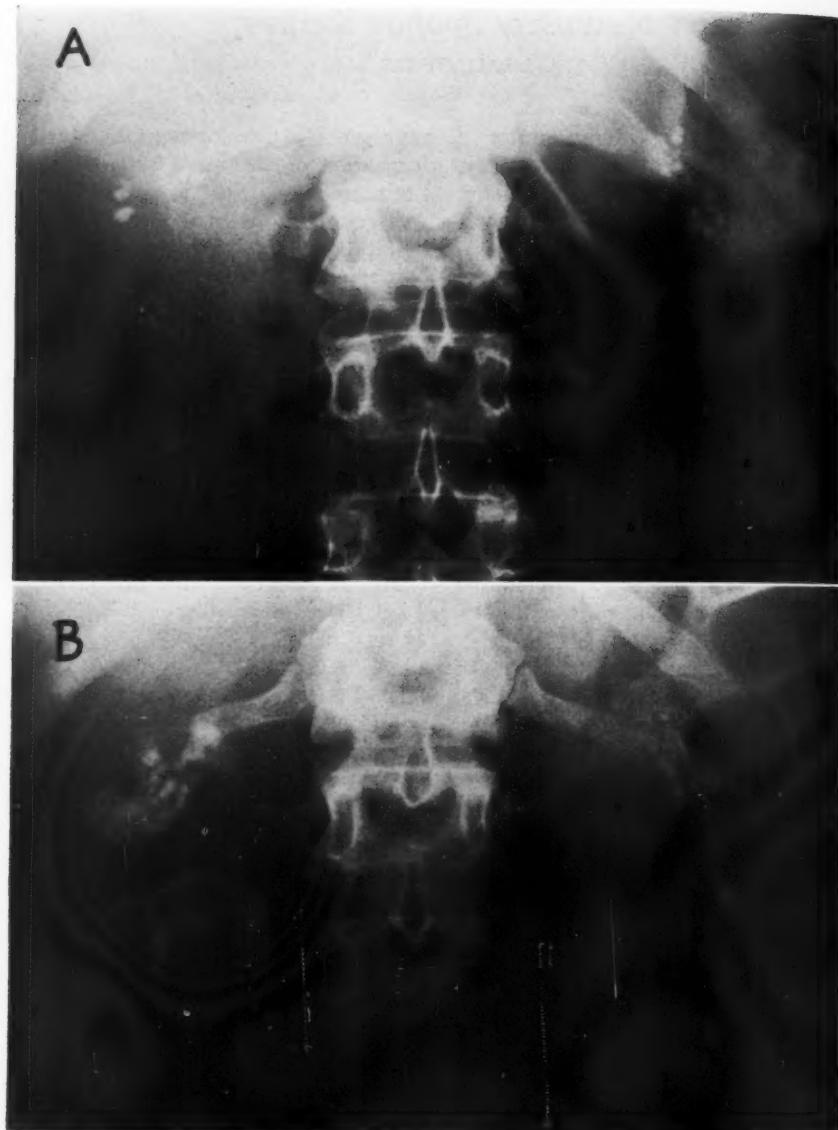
A 23-year-old white female with a history of recurrent attacks of frequency, dysuria, left flank pain, and fever for three and a half years. A plain film of the abdomen (A) and excretory urogram (B) demonstrate the classical picture of well developed medullary sponge kidney. Note the apparent "absence" of involvement in the lower two-thirds of the left kidney and the distribution and configuration of the many pyramidal concretions in both kidneys.
